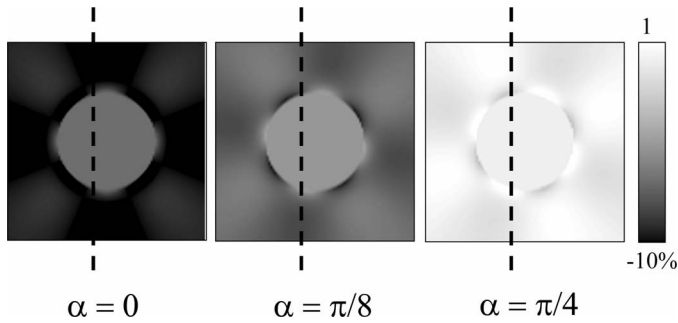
Images of the normal, axial strain component (ε_{yy}) of a homogeneous cylindrical inclusion that is two times harder than an otherwise homogeneous background. In the analytical solution used to create these images, the external load was applied at (left) $\alpha = 0$, (center) $\alpha = \pi/8$, and (right) $\alpha = \pi/4$ relative to the axial direction of an ultrasound beam. The strain profiles along the dotted lines are presented in Fig. 4.
